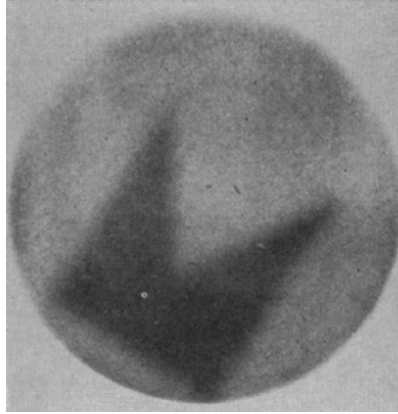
First published proton radiography [46].
